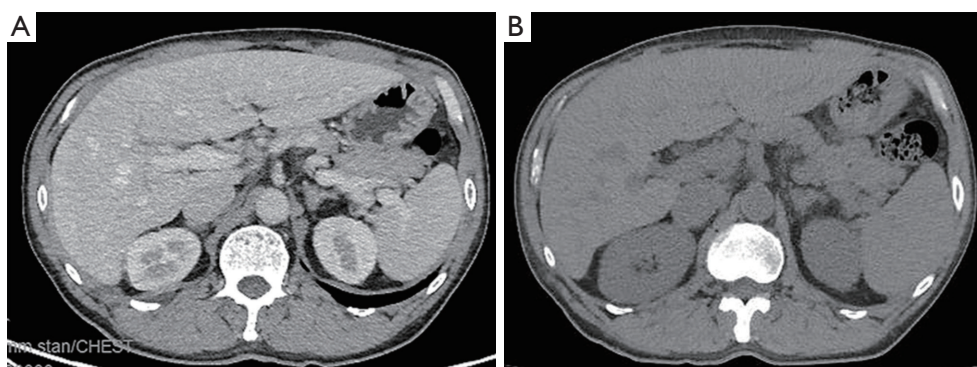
Comparison of spleen size in the second patient before any anti-tumor treatment and after the administration of pembrolizumab. (A) CT shows normal-sized spleen before any anti-tumor treatment. (B) CT shows splenomegaly 16 days after the administration of pembrolizumab. CT, computed tomography.
